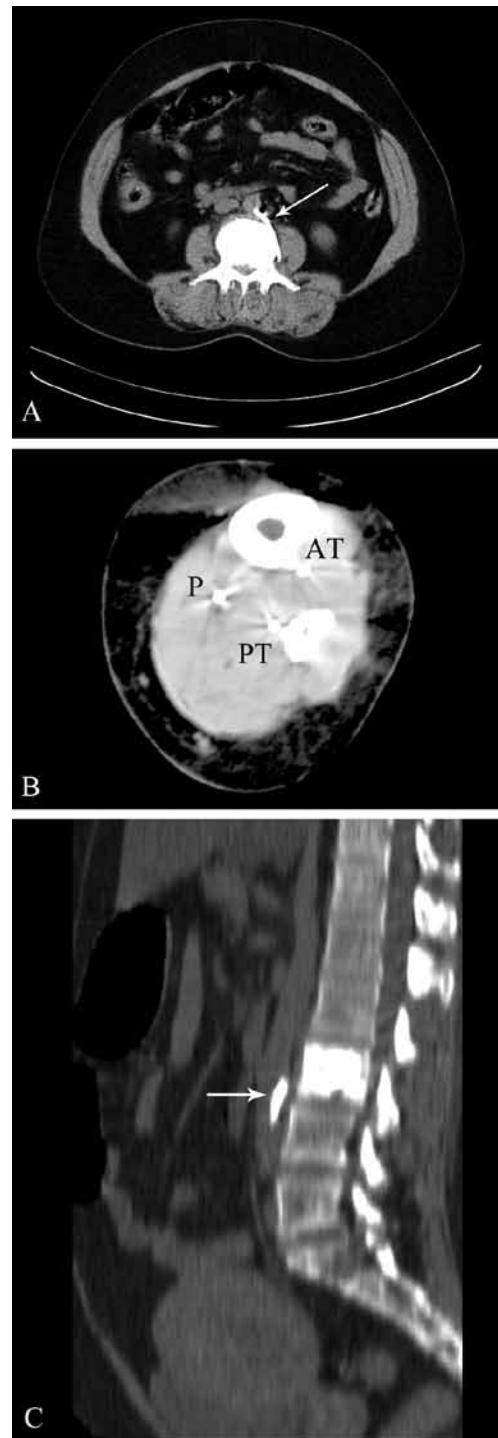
Abdominal and left leg CT scan without contrast: A, axial view with the bone setting at the level of the vertebroplasty demonstrates a leakage of acrylic cement in the lumbar artery supply to the aorta (long arrow); B, left lower limb CT reveals the cement embolus in the peroneal artery (P), anterior tibial artery (AT), and posterior tibial artery (PT); C, the thoracolumbar spine CT (sagittal view) shows the cement in the aorta (short arrow)
